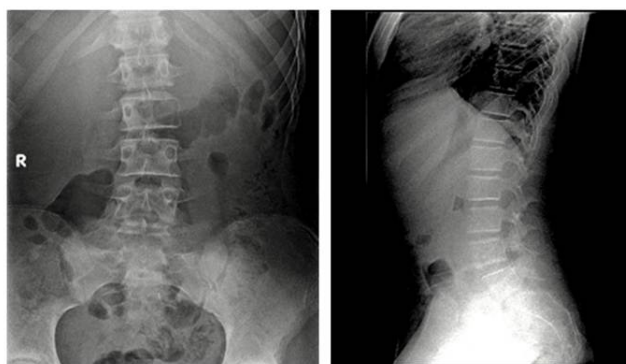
Plain radiography of the AP and lateral views of the LS spine
